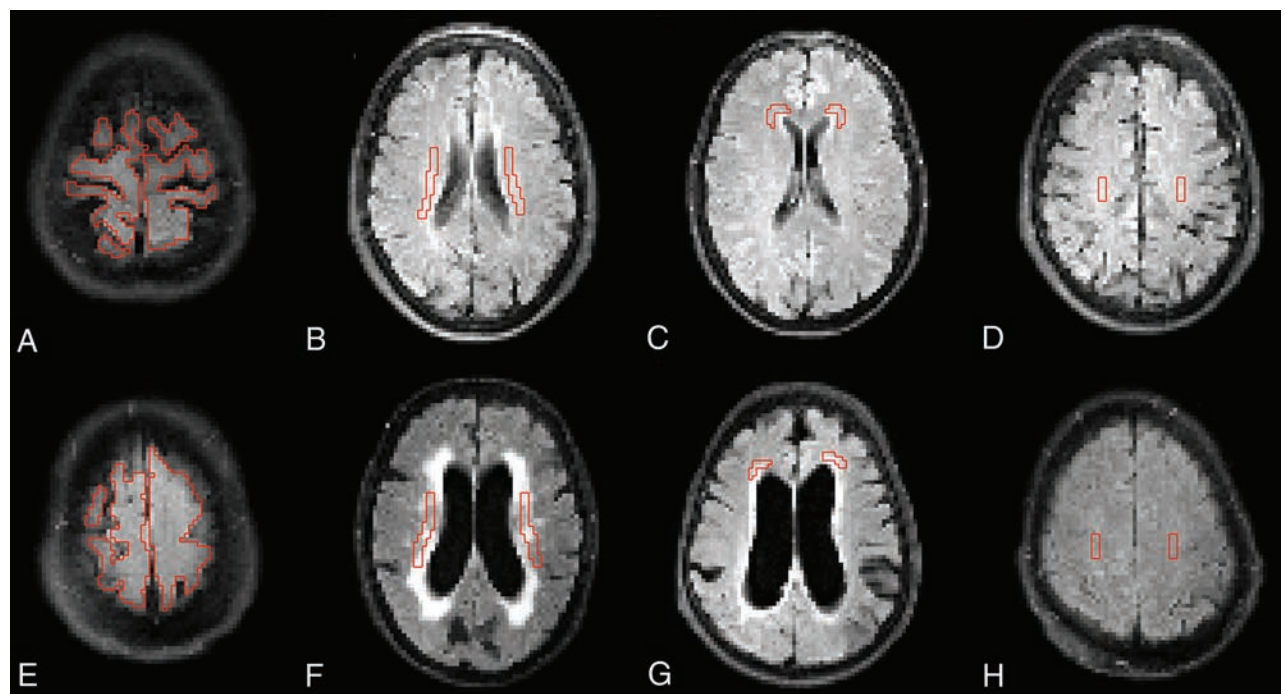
FLAIR images that were coregistered to the ASL images and used to draw ROIs. A–D, Healthy controls. E–H, Patients with iNPH. A and E, High-convexity cortex. B and F, Lateral periventricular WM. C and G, Frontal WM. D and H, Superior WM. All ROIs above were drawn in 2 adjacent sections, 1 of which is shown here.
